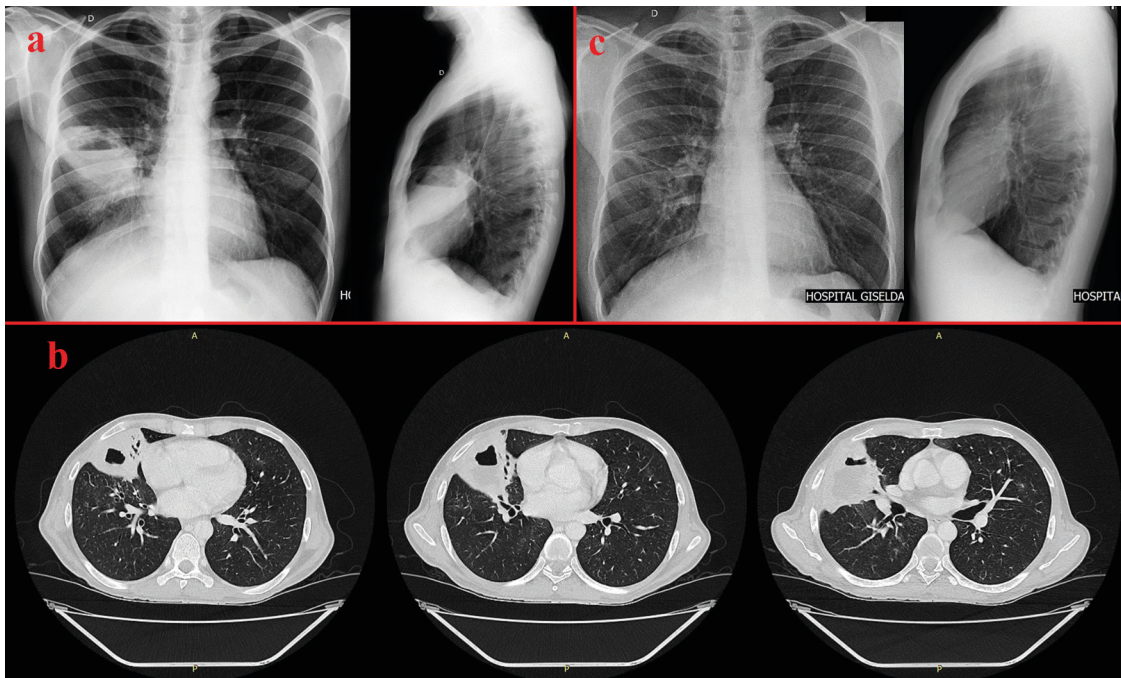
A) Chest X-ray showing a consolidation area with a thick -walled cavitation containing an air-fluid level in the right mid lung field on the patient's admission; B) Computed tomography showing a pleuropulmonary fluid-gas collection located in the right middle lung lobe; C) Chest X-ray showing linear fibrotic bands with cicatricial appearance in the right mid lung field four months after treatment for *Rhodococcus equi* pneumonia.
